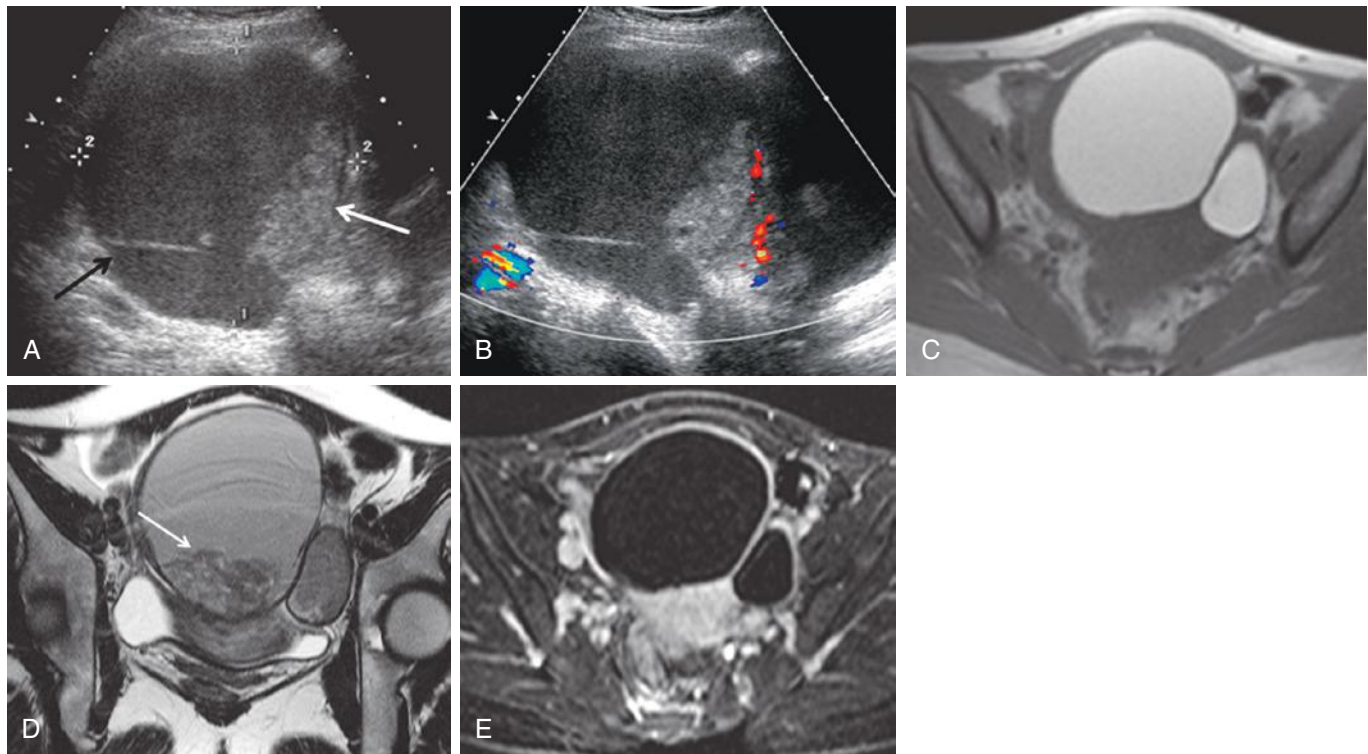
Complex endometrioma mimicking ovarian neoplasm. A, A 10-cm complex cystic mass (*calipers*) with septation (*black arrow*) and echogenic, lobulated mural nodule (*white arrow*). B, No flow was demonstrated in the nodule with color Doppler interrogation, suggesting the possibility of an adherent blood clot. C, Axial T1-weighted magnetic resonance (MR) image demonstrates that the lesion is T1-weighted hyperintense suggesting hemorrhagic content. Note adjacent smaller similar appearing lesion. D, Decrease in signal intensity within both lesions on T2-weighted axial MR image represents “shading.” A dependent clot is visible in the larger midline lesion (*arrow*). E, Postcontrast subtraction image demonstrates no enhancing solid component. Endometriomas were confirmed at surgery.
